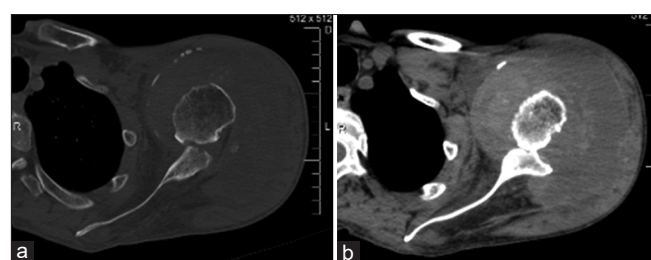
CT scan left shoulder: (a) Soft-tissue window. (b) Bone window
